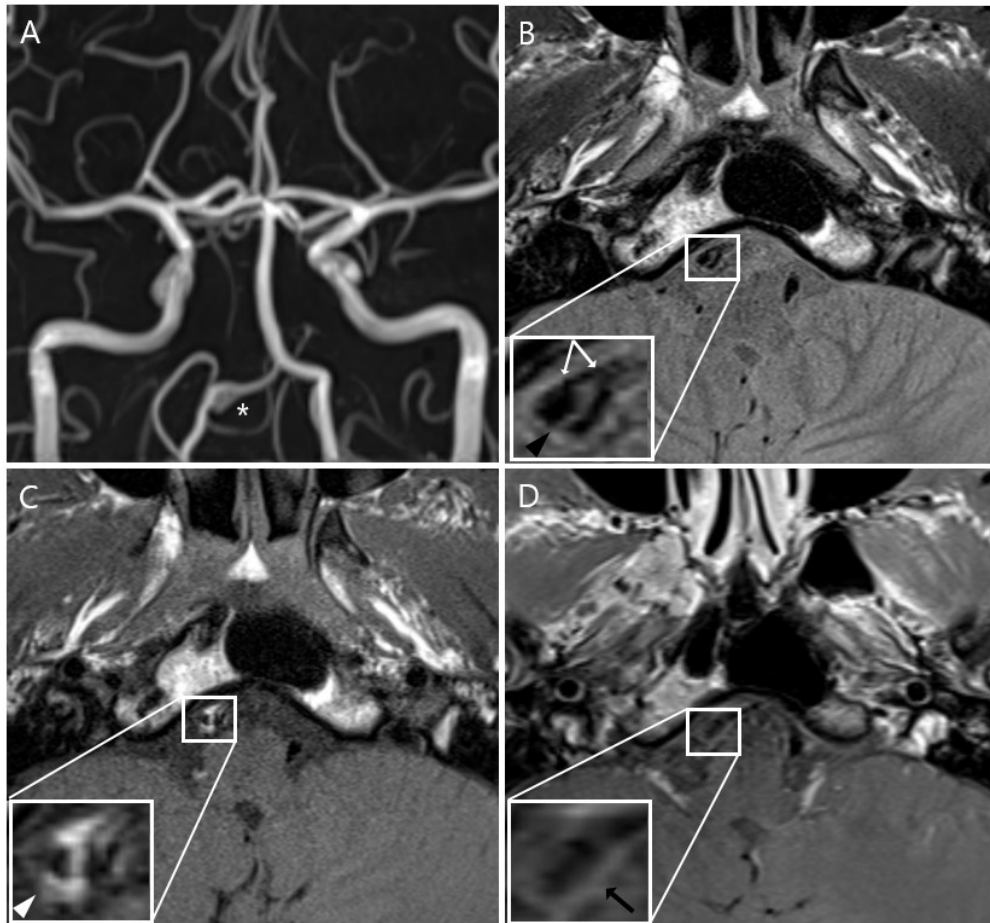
HRMRI images of the patient (A) Time-of-flight magnetic resonance angiograph showing dissecting aneurysm in the right vertebral artery (white star); (B) Proton density sequence showing the dissecting flap (black arrowhead) and the double lumen, (white arrow); (C) T1-weighted image of HRMRI showing eccentric intramural hematoma (white arrowhead); (D) Contrast-enhanced T1-weighted image of HRMRI showing no significant enhancement of intramural hematoma.
